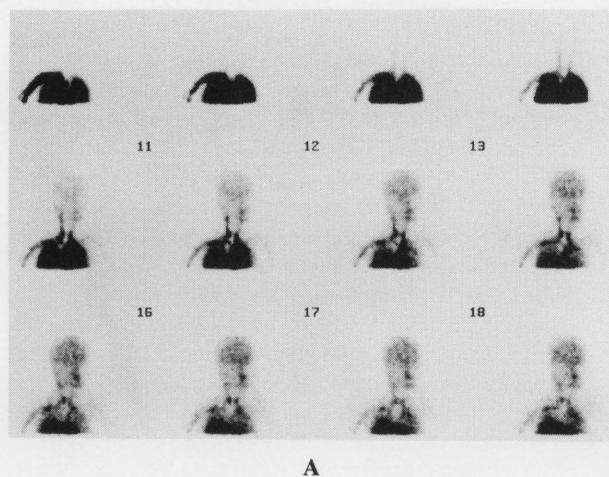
Follow up Technetium-99m hexamethylpropylene amine oxime, dynamic study showing a decrease in the uptake of nasal area (A). Single photon emission computed tomography oblique hemispheric (B) showing hypoperfusion in the parietal, temporal and occipital lobes of cerebral hemisphere.
